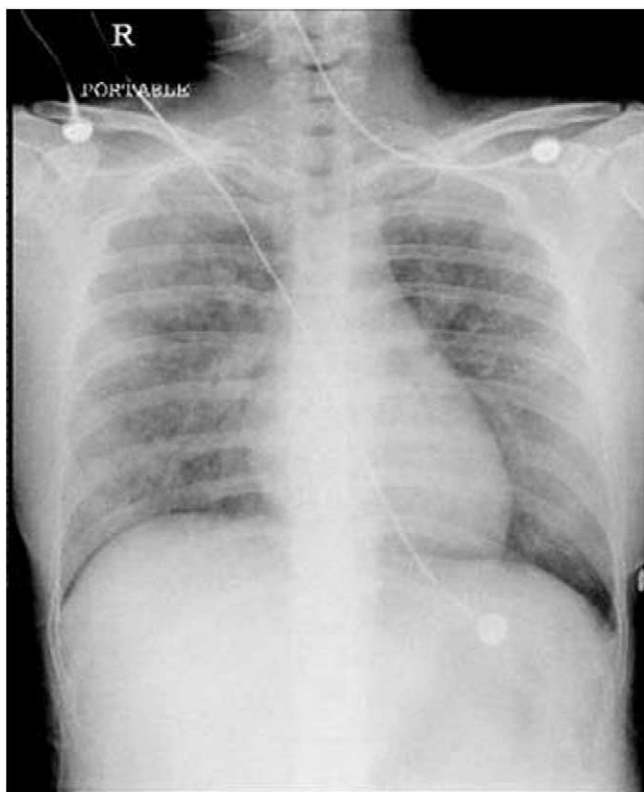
Case 2 chest radiograph showing pulmonary edema.
